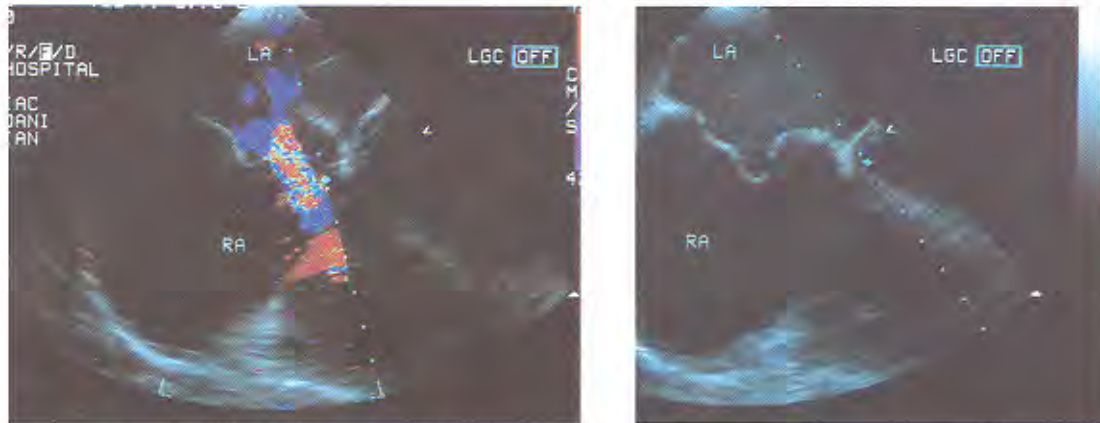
(left) Transesophageal echocardiogram with color-flow mapping, showing the presence of ASA and its associated ASD.
